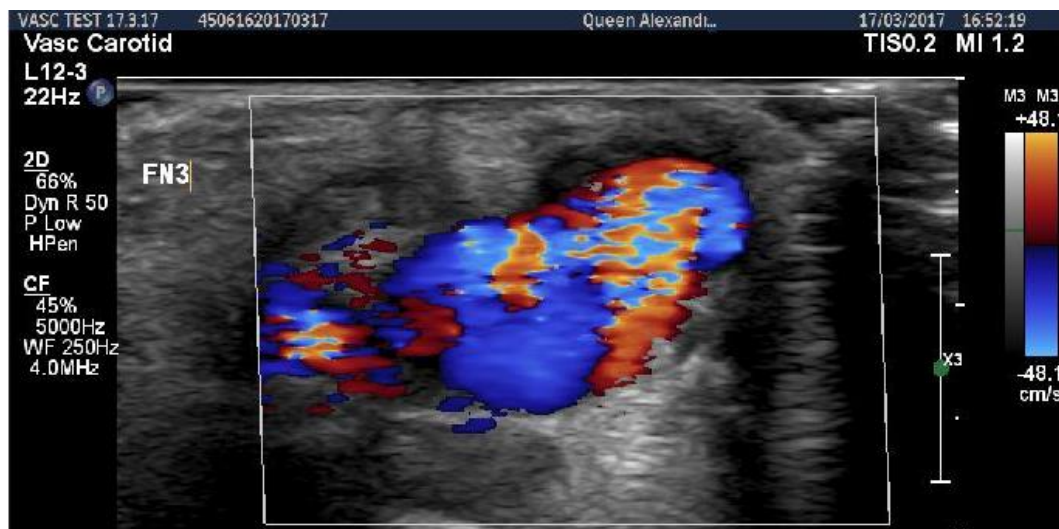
Ultrasound Colour-Doppler scan at the anastomosis to evaluate blood velocity magnitude and patterns.
